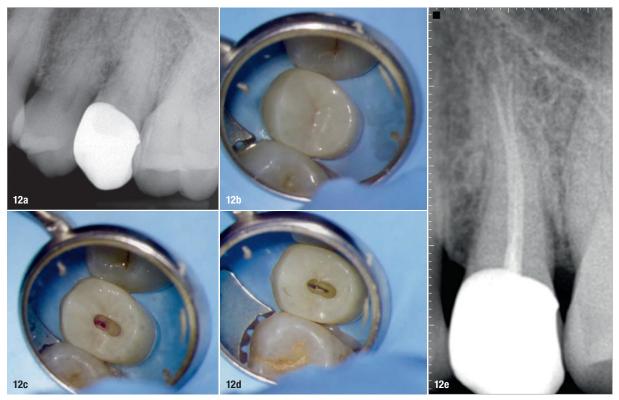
Initial situation (a). The restorative material (b) was leveraged, leading to a buccally positioned access cavity (c & d). Radiograph of the tooth, which was immediately restored at the time of obturation. (e). The one-year follow-up showed radiographic healing, and the patient was asymptomatic and functional (f). (Case treated by Dr Dale Jung)
